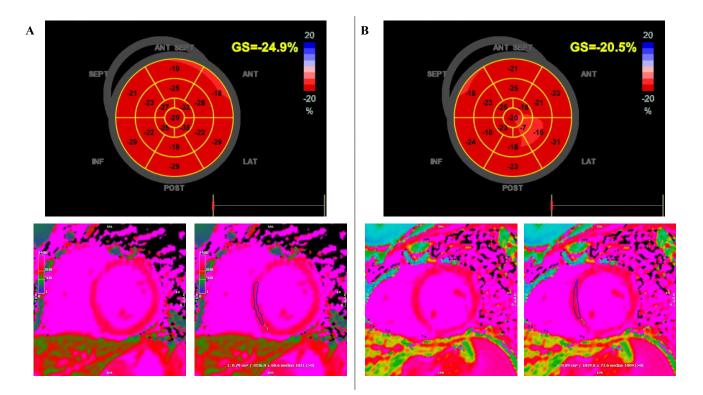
Global longitudinal strain at echocardiography and native T1 at cardiac magnetic resonance of the two sisters of the proband ((A): III-2; (B): III-3)) that showed no cardiac involvement.
